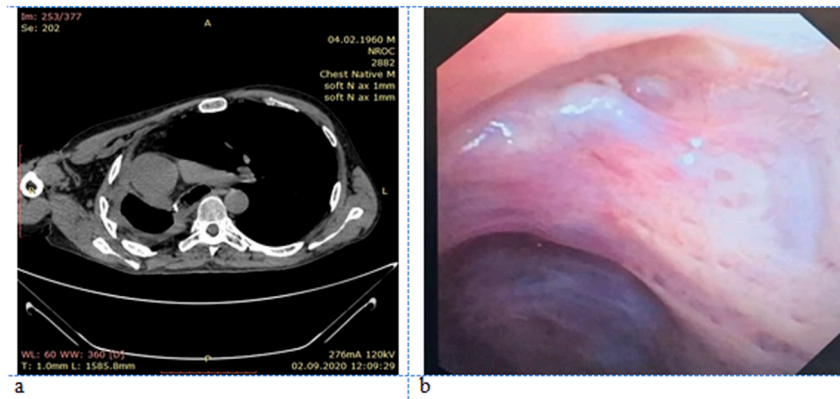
CT and bronchoscopy control after 6 months.
